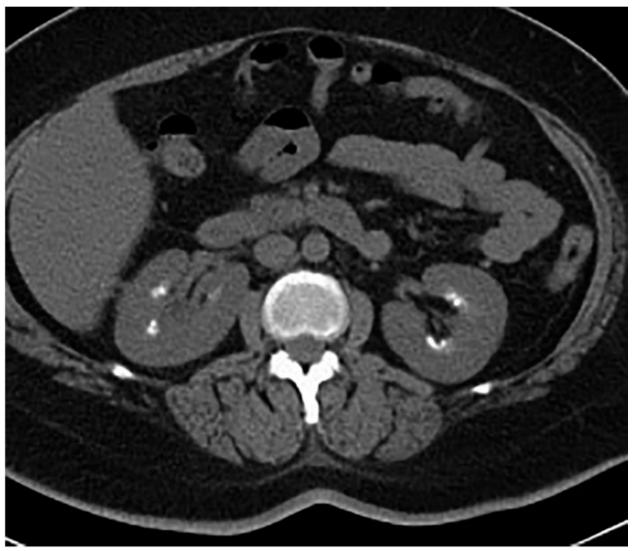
Medullary nephrocalcinosis. Axial and coronal noncontract computed tomogram showing amorphous and course pyramidal calcifications in both kidneys consistent with medullary nephrocalcinosis.
